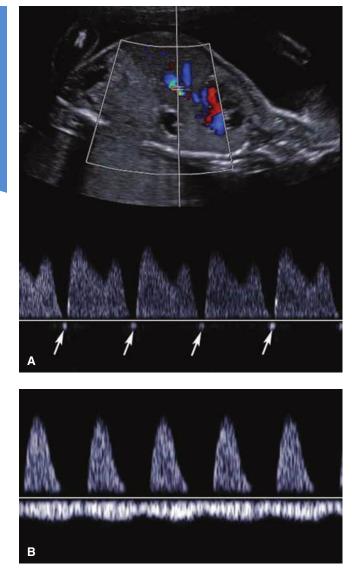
Venous Doppler abnormalities. A. Reversal of a-wave flow in the ductus venosus. Arrows depict a-waves below the baseline. This finding may be identified with cardiac dysfunction in the setting of severe fetal-growth restriction. B. Pulsatile flow in the umbilical vein. The undulating umbilical venous waveform below the baseline indicates tricuspid regurgitation. Above the baseline is the umbilical artery waveform, in which there is no visible end-diastolic flow. Because the venous waveform is below the baseline in this image, it is not possible to determine whether the umbilical artery end-diastolic flow is reversed.
